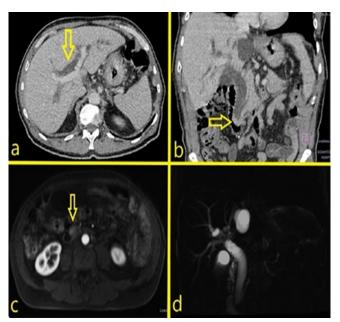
Preoperative upper abdominal computed tomography (a,b) and resonance image study (c,d). a) Contrast enhanced computed tomography, axial plane, disclosing intrahepatic bile duct dilatation (yellow arrow); b) Contrast enhanced computed tomography, coronal plane, disclosing main bile duct and pancreatic duct and nodular lesion on the ampulla of Vater (yellow arrow); c) Contrast enhanced magnetic resonance, axial plane, disclosing ampullary lesion; d) Contrast enhanced magnetic resonance, coronal plane, disclosing main bile duct, intrahepatic bile duct and main pancreatic duct dilatation.
